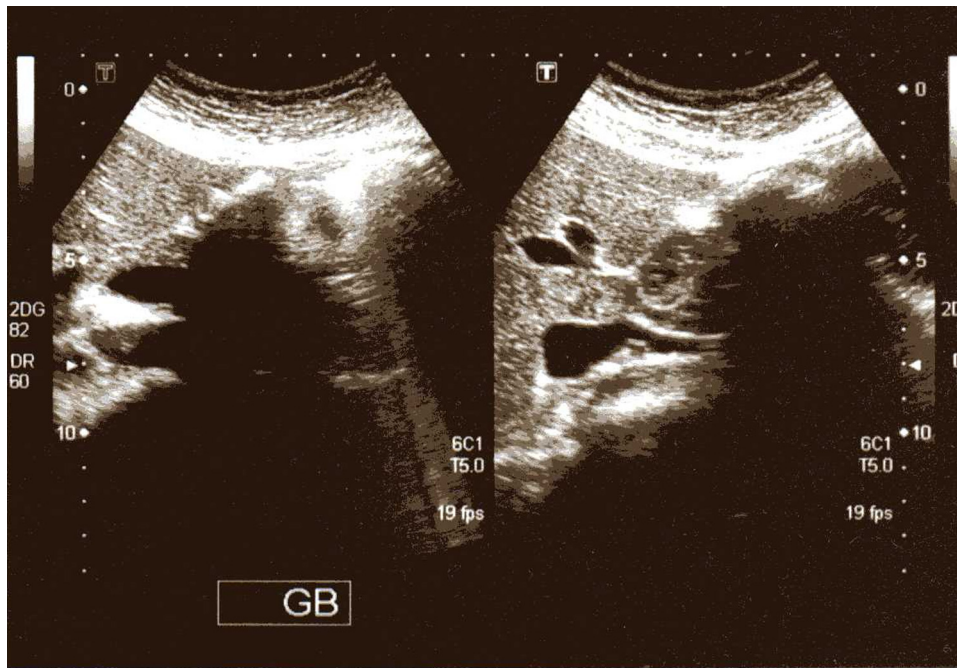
Case 1: Abdominal ultrasound of the abdomen. Multiple gallbladder stones with extensive acoustic shadowing. Left-sided gallbladder could not be identified.
